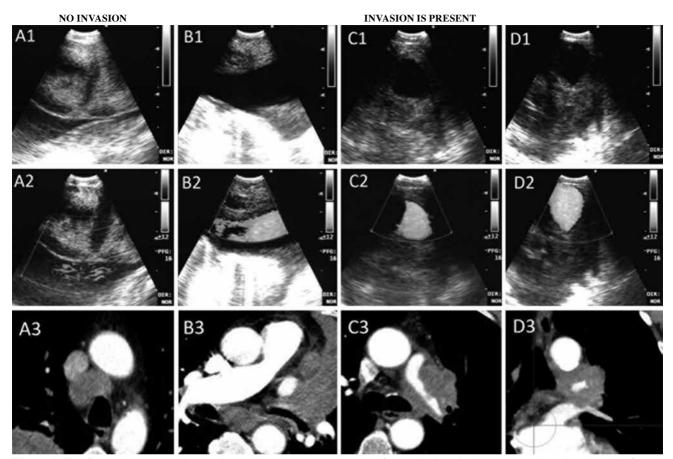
The figure shows several examples on the presence or absence of vascular invasion by tumor or lymph nodes. All figures are presented with their corresponding power Doppler images. A1 and A2: A distinct hyperechoic line is clearly and continuously seen between lesion and vessel (superior vena cava in this example). There is no sign of invasion. B1 and B2: The lesion invades left inferior pulmonary vein. The hyperechoic line cannot be seen thoroughly. C1 and C2 (also in D1 and D2): The lesion invades left main pulmonary artery. The hyperechoic line is vanished. Vessel wall becomes irregular by tumor cells protruding through the lumen. A3 to D3: Corresponding computed tomography images of the same patients. Note that scanning angle of EBUS may differ from the simple transverse and coronal/sagittal images of computed tomography.
